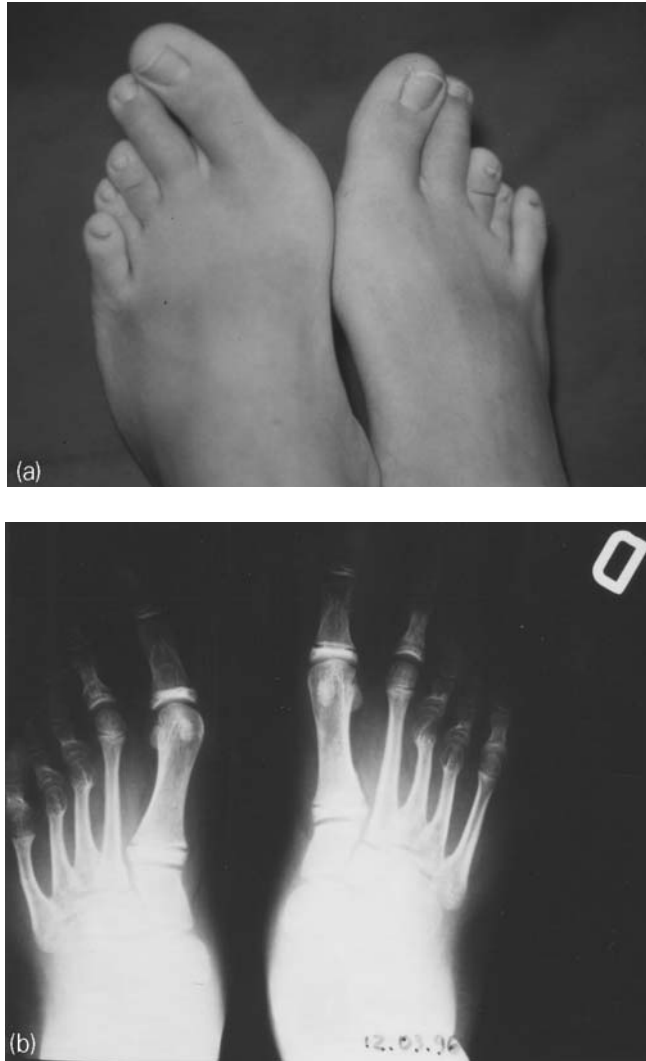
A 13-year-old girl with Turner's syndrome. Bilateral shortening of the third and fourth metatarsals. (a) Clinical photograph before treatment. (b) Radiograph before treatment. (c) Treatment plan: simultaneous lengthening of the third and fourth metatarsal bones. (d) Radiograph of the left foot during lengthening. (e) Radiograph of the right foot during lengthening. (f) Radiograph taken 6 months after removal of the apparatus. (g) Clinical photograph after bilateral lengthening. Duration of treatment was 3 months for the left foot and 4 months for the right foot. There were no complications during treatment.
